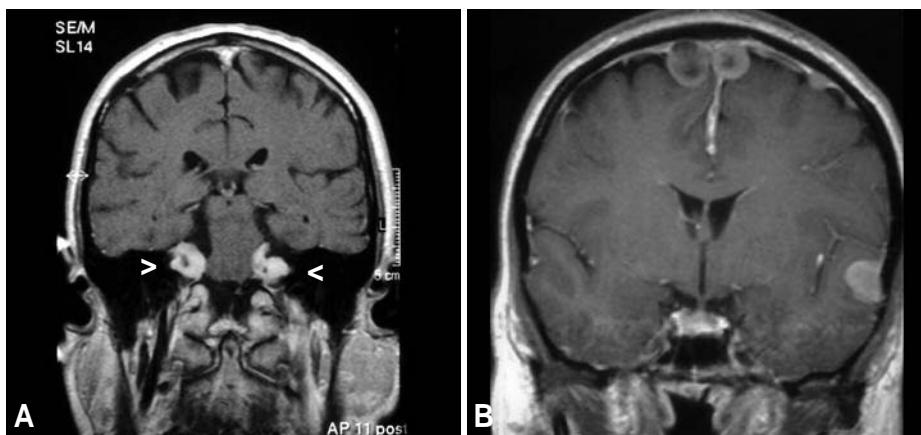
T1-weighted, contrast-enhanced MR images from patients with NF2. A Bilateral acoustic schwannomas (arrows), the diagnostic hallmark of NF2. B Multiple meningiomas presenting as contrast-enhanced masses.
